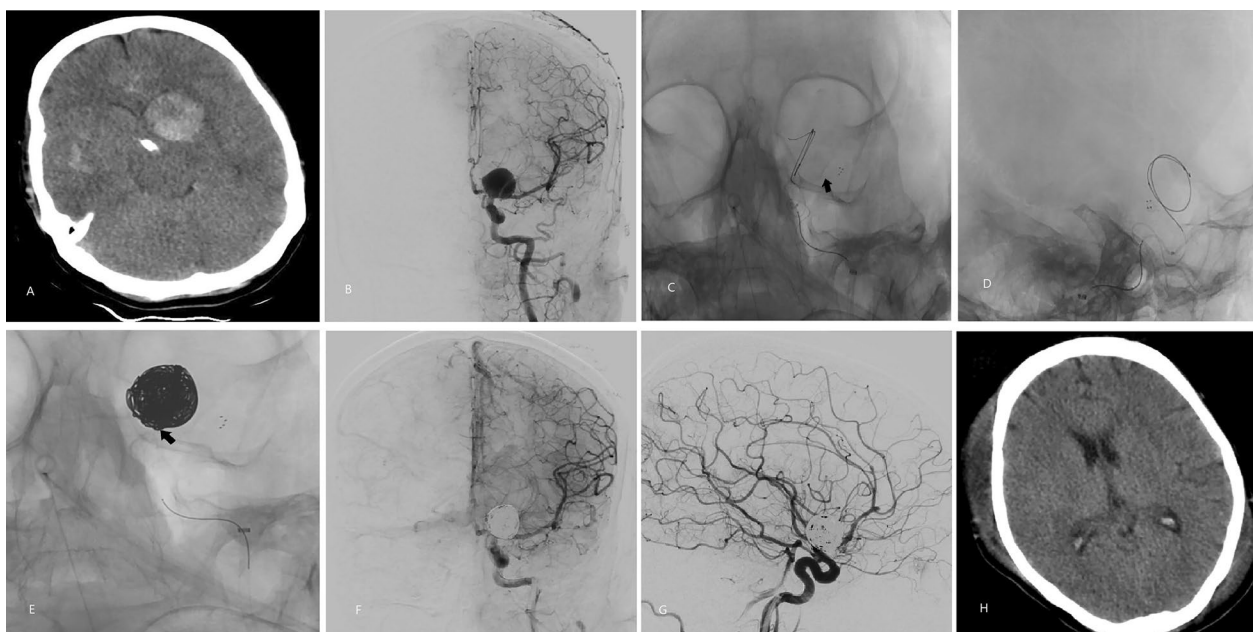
A Brain CT scan showed diffuse SAH and aneurysm (arrow), B brain angiogram (AP) showed a large aneurysm in the left ICA bifurcation, left ACA junction, and left MCA bifurcation, C, D single shot during angiogram showed solitaire FR, deployed in parent artery across the aneurysm neck (arrow), E probable site of coil entrapment in solitaire FR (arrow), F, G brain angiogram (AP and lateral) after aneurysm closure with coils at the end of procedure, and H brain CT scan at day 4th, showing no infarct
